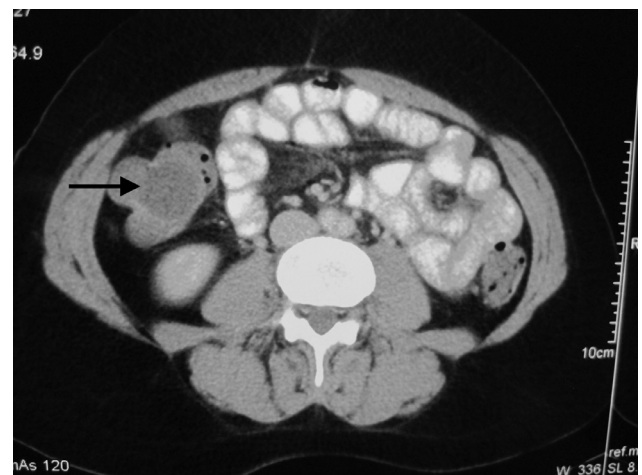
Computed tomography of the abdomen showing multicystic lesions.
